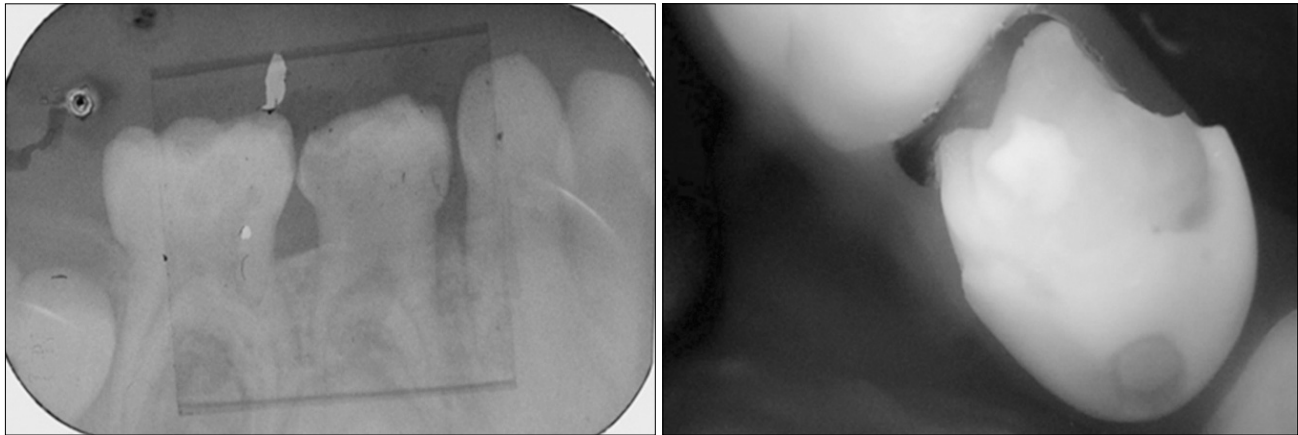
Radiography and photographing of the Qraypen™ image.
